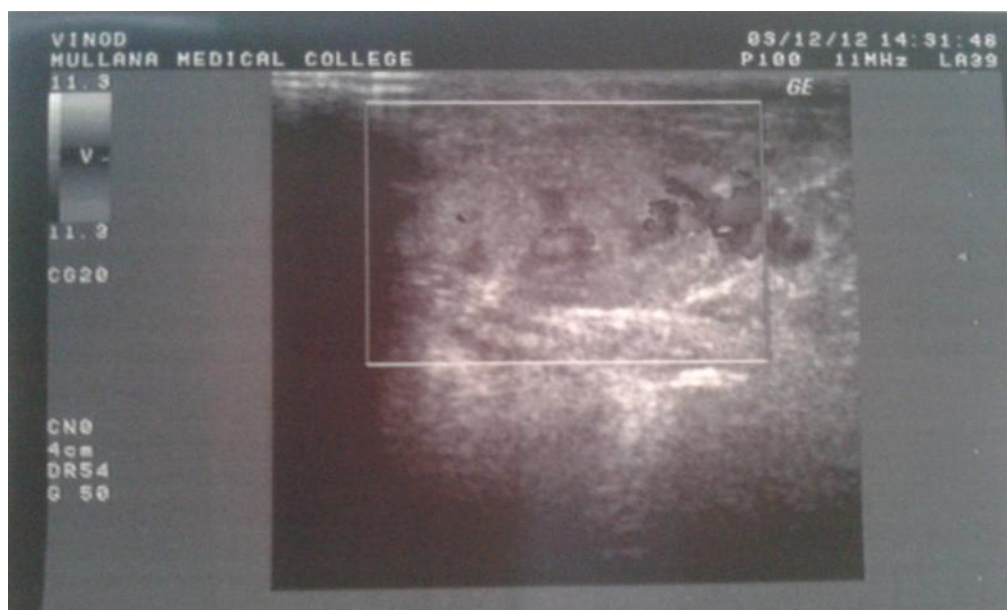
Color Doppler US reveals low velocity venous flow along with feeding vessels.
